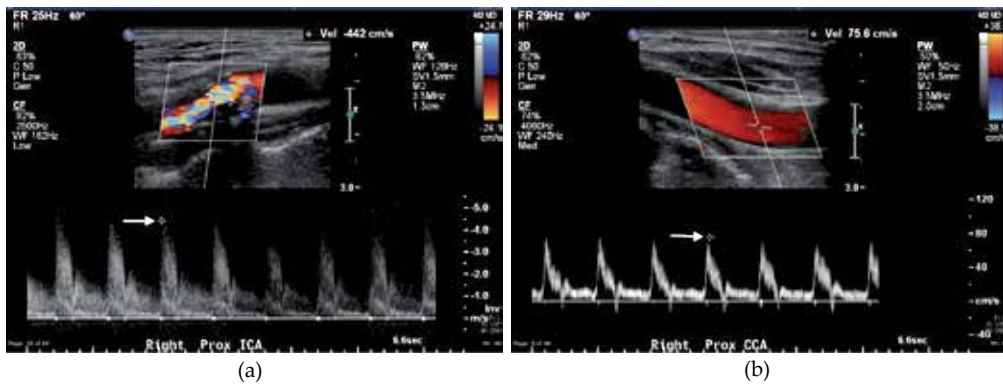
71 year old male presenting with history of transient ischemic attack presenting as left arm numbness and weakness. A. Ultrasound of the right internal carotid artery showing elevated velocities (arrow) up to 442 cm/s correlating with a greater than 70% stenosis by NASCET criteria. B. Same patient US of right proximal common carotid artery with baseline velocities (arrow) 75.6 cm/s.
